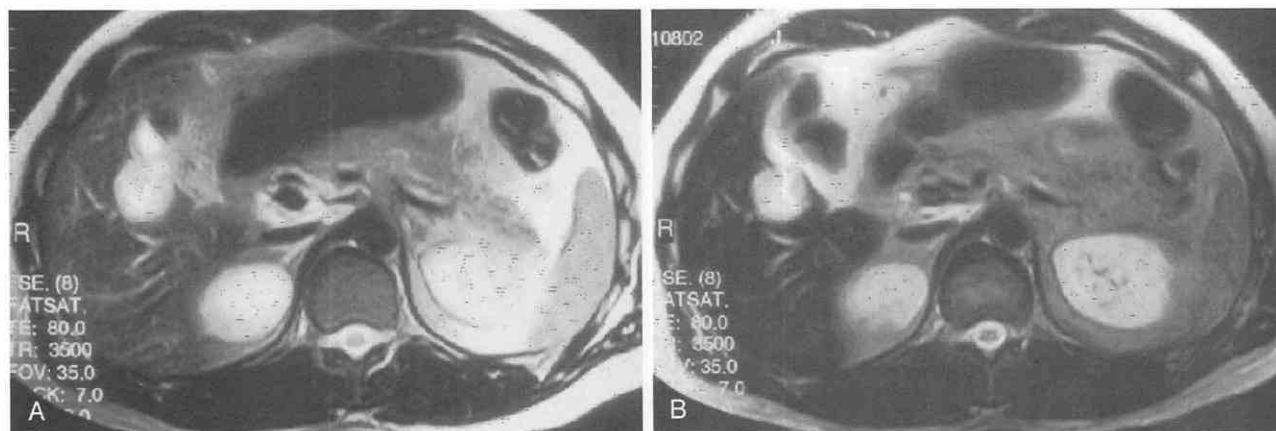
Liver metastasis. *A*, Unenhanced T2-weighted image demonstrates a single bright lesion. *B*, T2-weighted image after administration of superparamagnetic iron oxide (SPIO) reveals loss of signal in the hepatic parenchyma without loss of signal in the lesion.
